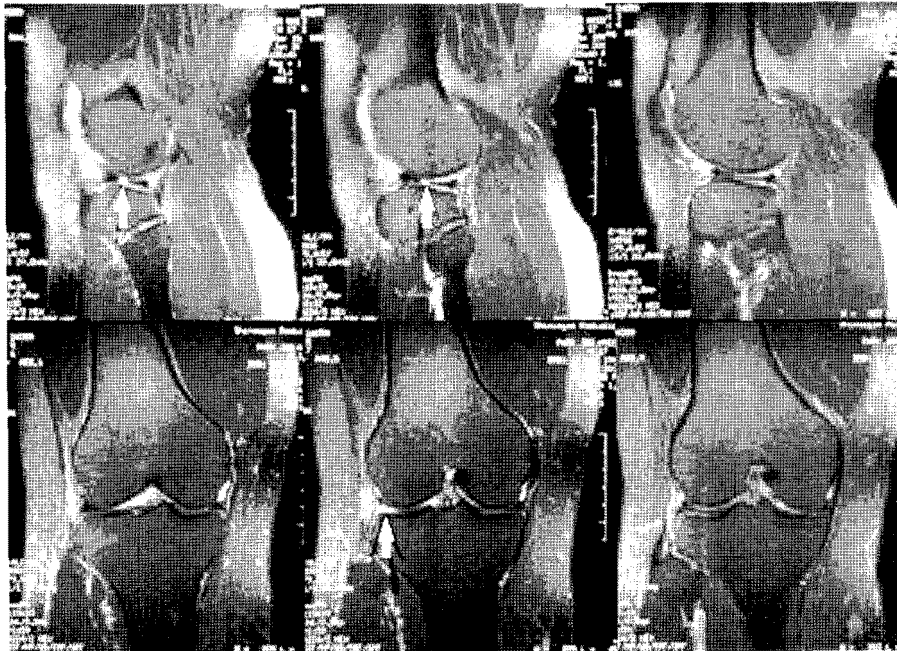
Preoperative MRI shows a radial tear (arrows) in the lateral meniscus on sagittal (A) and coronal views (B).
